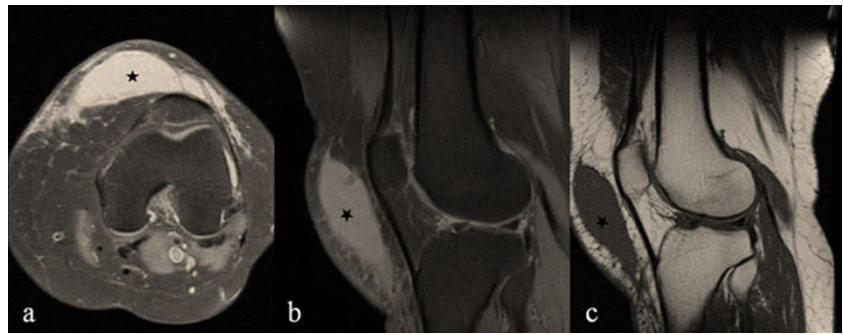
Prepatellar bursitis*. The axial (a), sagittal (b) fat saturated proton density weighted and the sagittal (c) T1-weighted images demonstrate a distended prepatellar bursa (asterisk)
